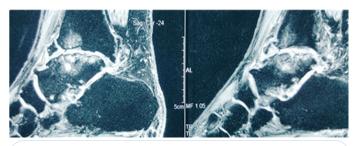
Patient 2: 47 years old male patient with grade 4 PTOA after Talus fracture fixation. Ankle MRI, 9 years after fracture and before MSC treatments.
